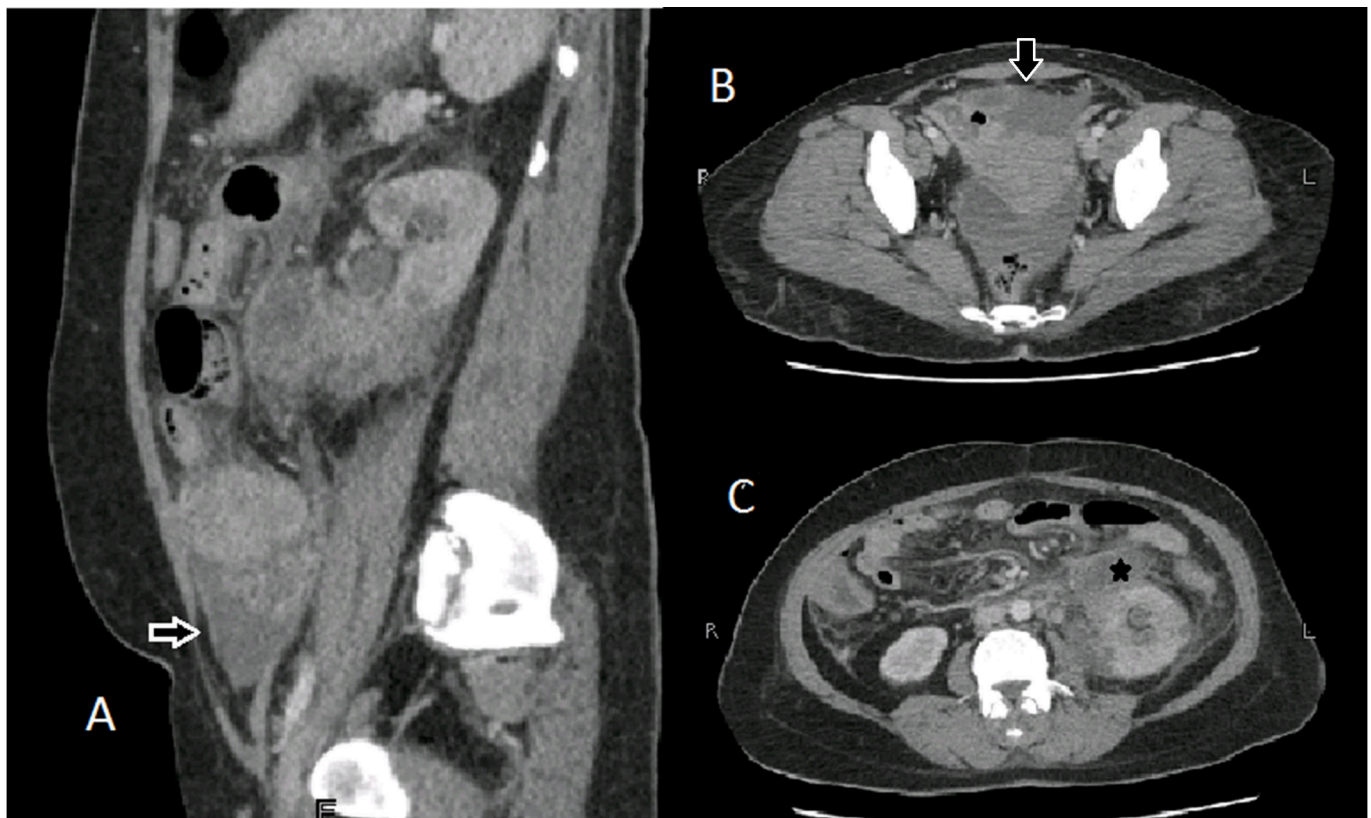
CT abdomen showing intraperitoneal collection (A and B, black arrow) along with perinephric collection (C, asterisk*).
